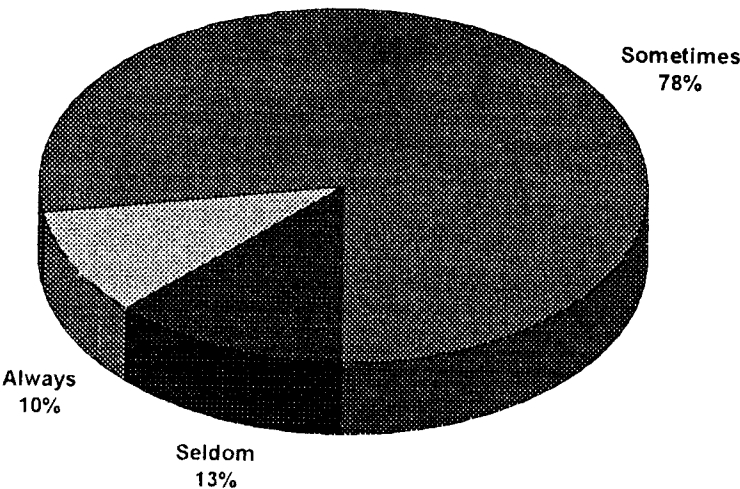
Use of radiographs in dental check-up
